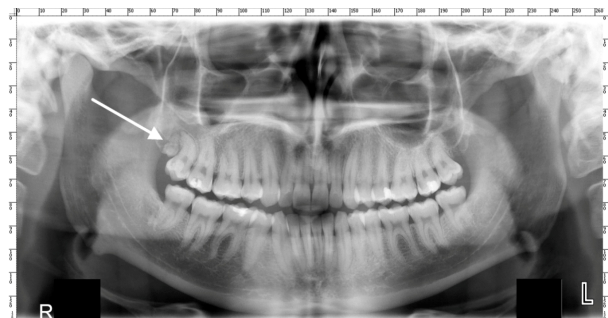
Panoramic radiological investigation showing the presence of one distomolar in the right part of the upper jaw. R: Right; L: Left.
